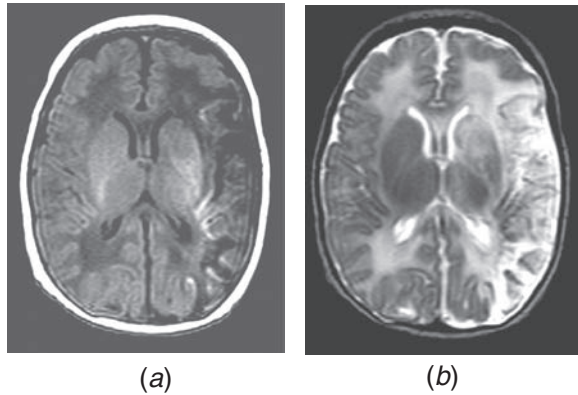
Perinatal left-sided middle cerebral artery infarction in a term-born infant: (a) T1- and (b) T2-weighted images. There is abnormal signal intensity within the basal ganglia, thalami, and posterior limb of the internal capsule, in addition to the parenchymal white matter and cortex. These changes would be associated with the later development of a right-sided hemiplegia.
